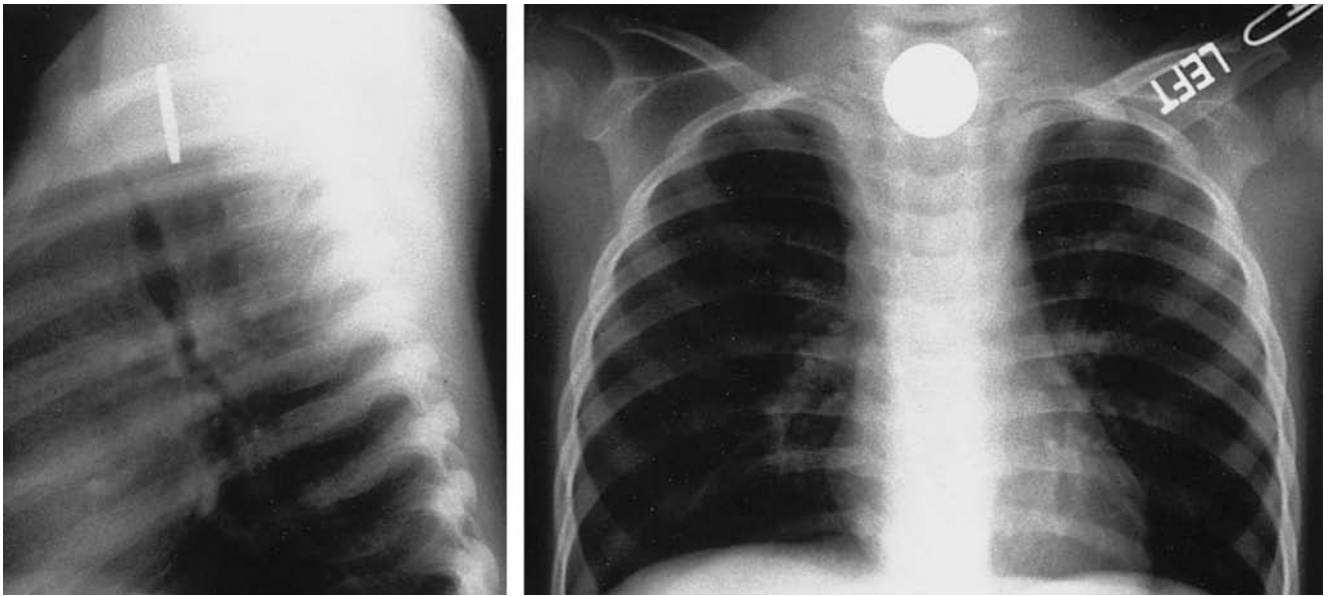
Two-view chest radiograph demonstrating impacted esophageal coin located at the thoracic inlet.
